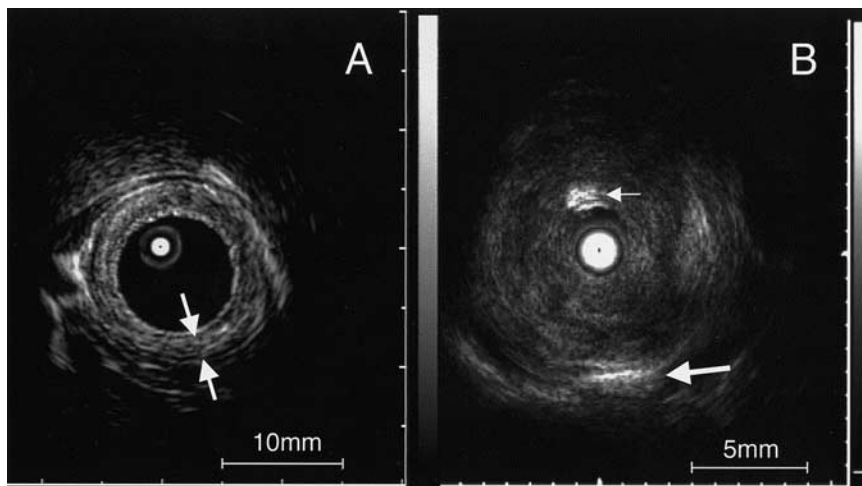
(A) Ultrasonography of the esophageal narrowing in case 1. The muscular layer (white arrows) is thickened to 2.5 mm. (B) Ultrasonography of esophageal narrowing in case 2. Two pieces of cartilage are seen as hyperechoic lesions. Small white arrow indicates cartilage just underneath the esophageal mucosa. Large white arrow indicates cartilage located deep in the muscle layer.
